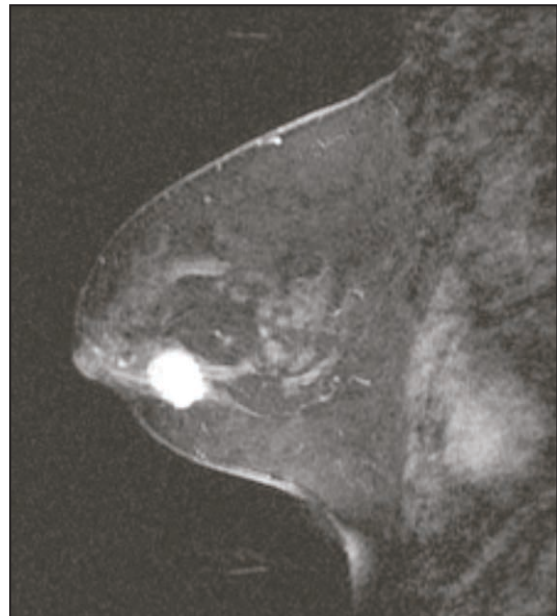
MRI mammography (Invasive carcinoma breast)
